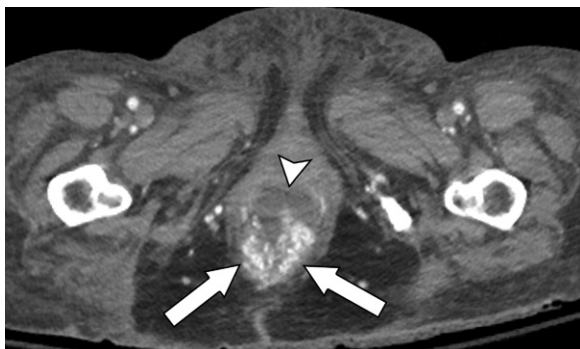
Rectal and perirectal varices in an 80-year-old woman with cirrhosis, portal hypertension, and ascites. Axial portal venous phase CT image shows multiple enhancing distended veins in the region of the rectum and the perirectal region that are consistent with varices (arrows). A small amount of ascites is also noted anterior to the rectum (arrowhead).
